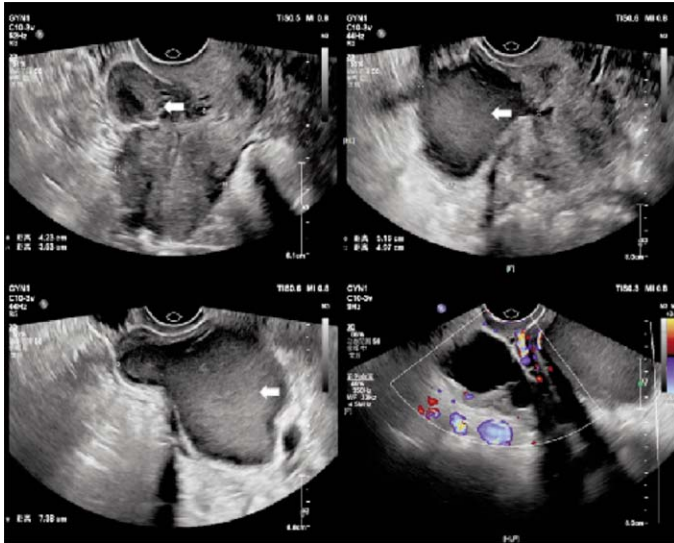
Gynaecologic ultrasound image.
